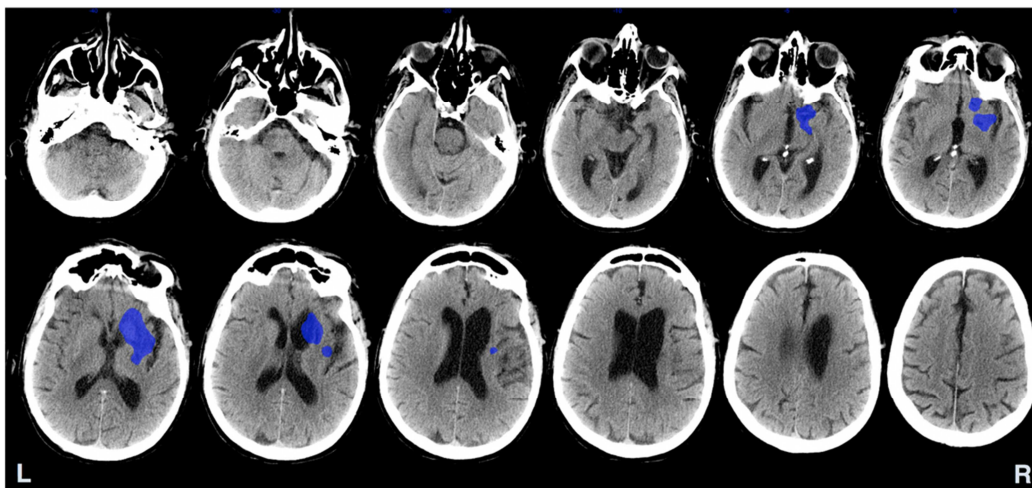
CD's clinical CT scan and corresponding lesion mask.
